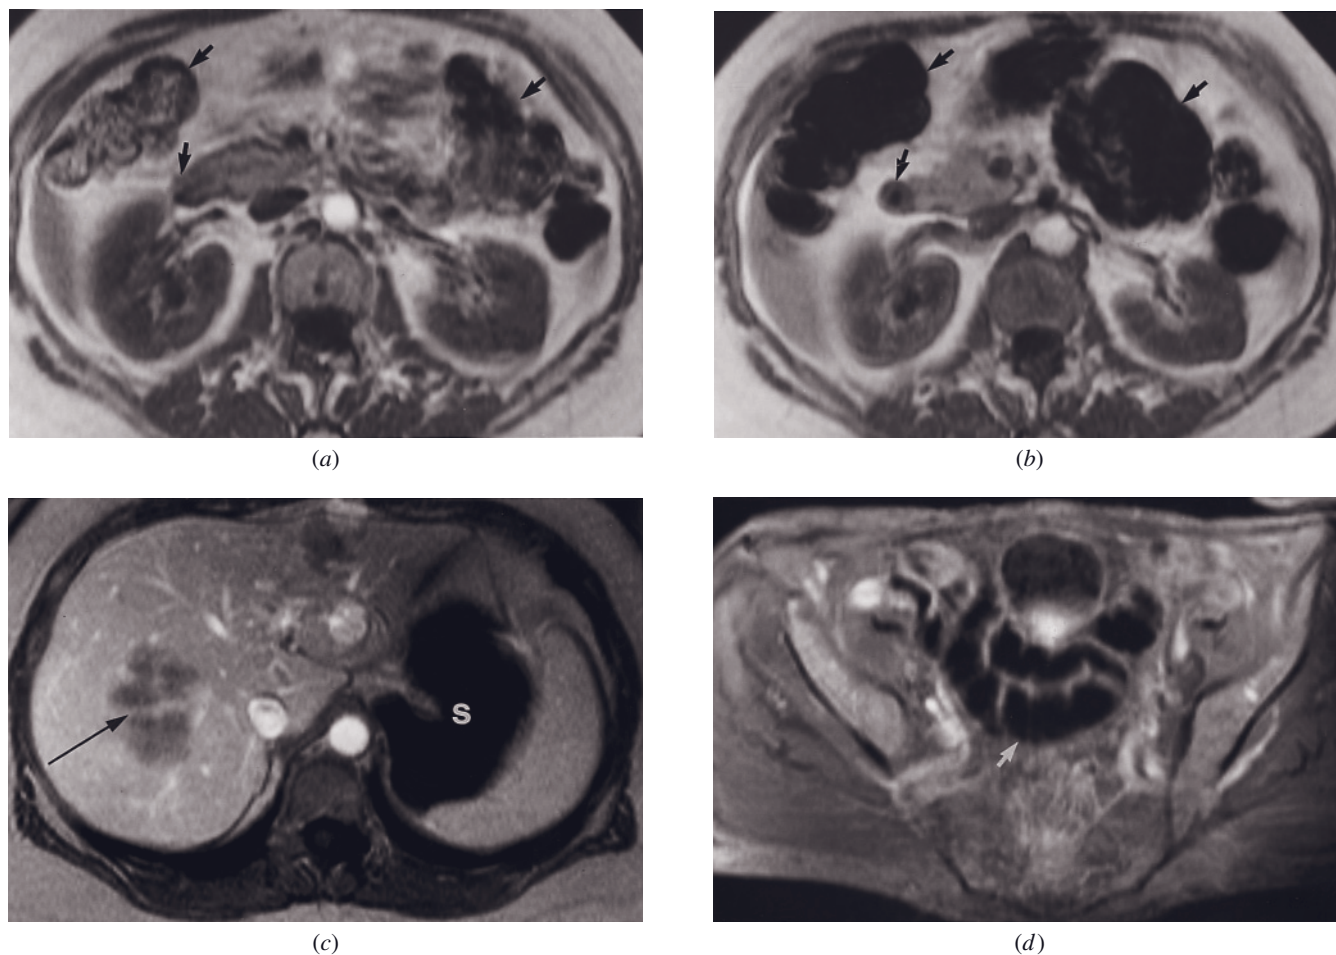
Negative oral contrast agent. SGE images before (a) and after (b) perfluorooctylbromide (PFOB) ingestion, intravenous gadolinium-enhanced SGE image after PFOB ingestion (c), and gadolinium-enhanced T1-weighted fat-suppressed spin-echo image after PFOB ingestion (d) in three patients. In the first patient (a, b), bowel contents are heterogeneous before PFOB intake (arrows, a), but after ingestion of PFOB they become nearly signal void (arrows, b). PFOB is signal void in the stomach (s, c) of a woman with hepatic metastases (arrow, c) from cervical carcinoma. In a third patient (d), distal small bowel is signal void (arrow, d) after PFOB administration. Oral agents distend the bowel, which may aid detection of mucosal abnormalities.
